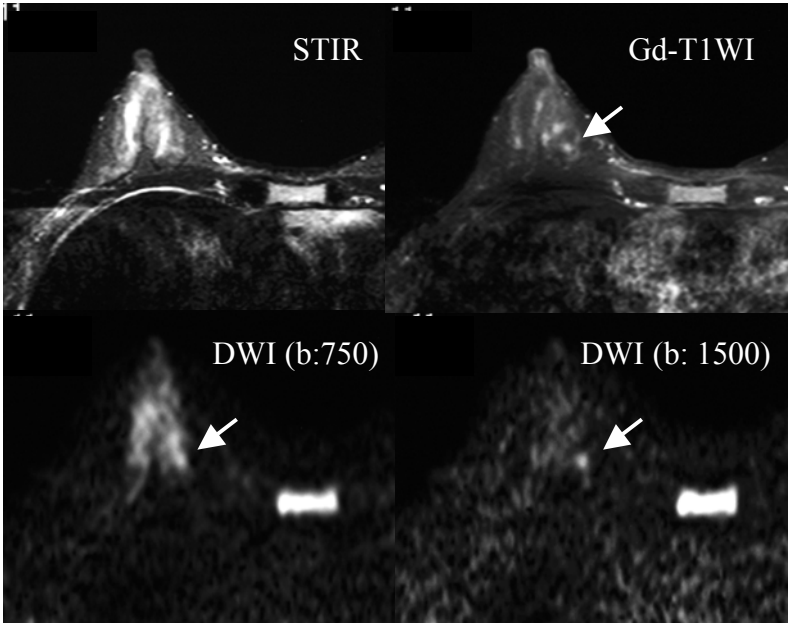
MR images of a DCIS case
